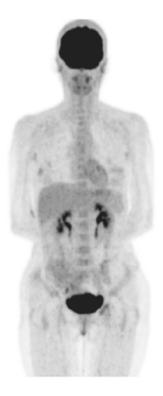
The distribution of FDG within a normal individual (MIP).
